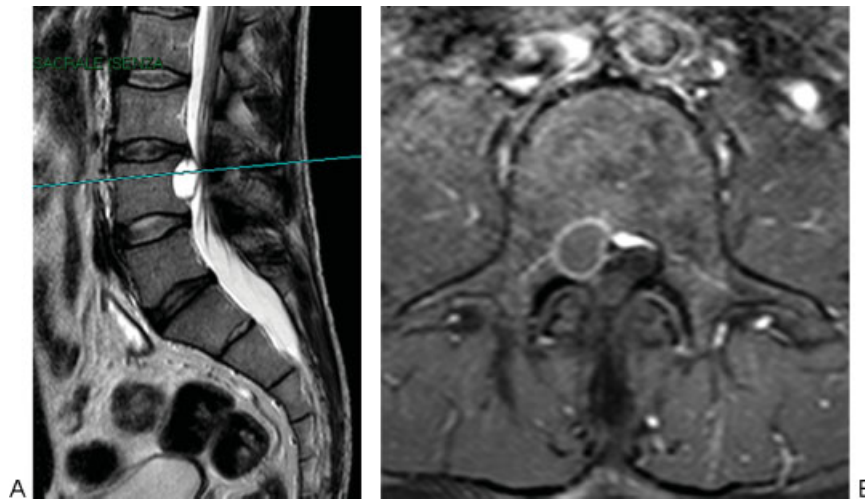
Sagittal T2-weighted (A) and axial T1-weighted postgadolinium enhancement (B) MRI of the lumbar spine demonstrates a spherical intraspinal, extradural cystic lesion originating from the L3–L4 disc and extending either laterally to the right side or caudally behind L4 vertebral body. Noticeable is the ring enhancement around the cyst. MRI, magnetic resonance imaging.
